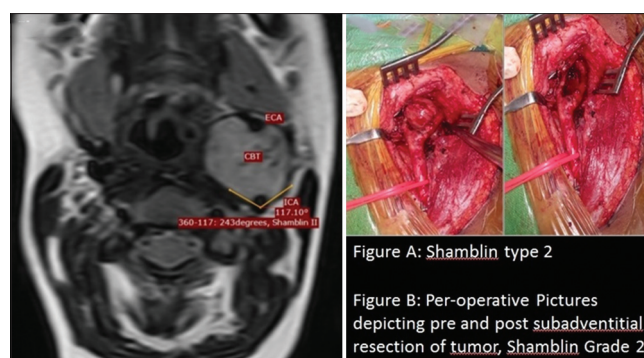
Shamblin Grade II: Axial T2-weighted magnetic resonance imaging versus per-operative picture
